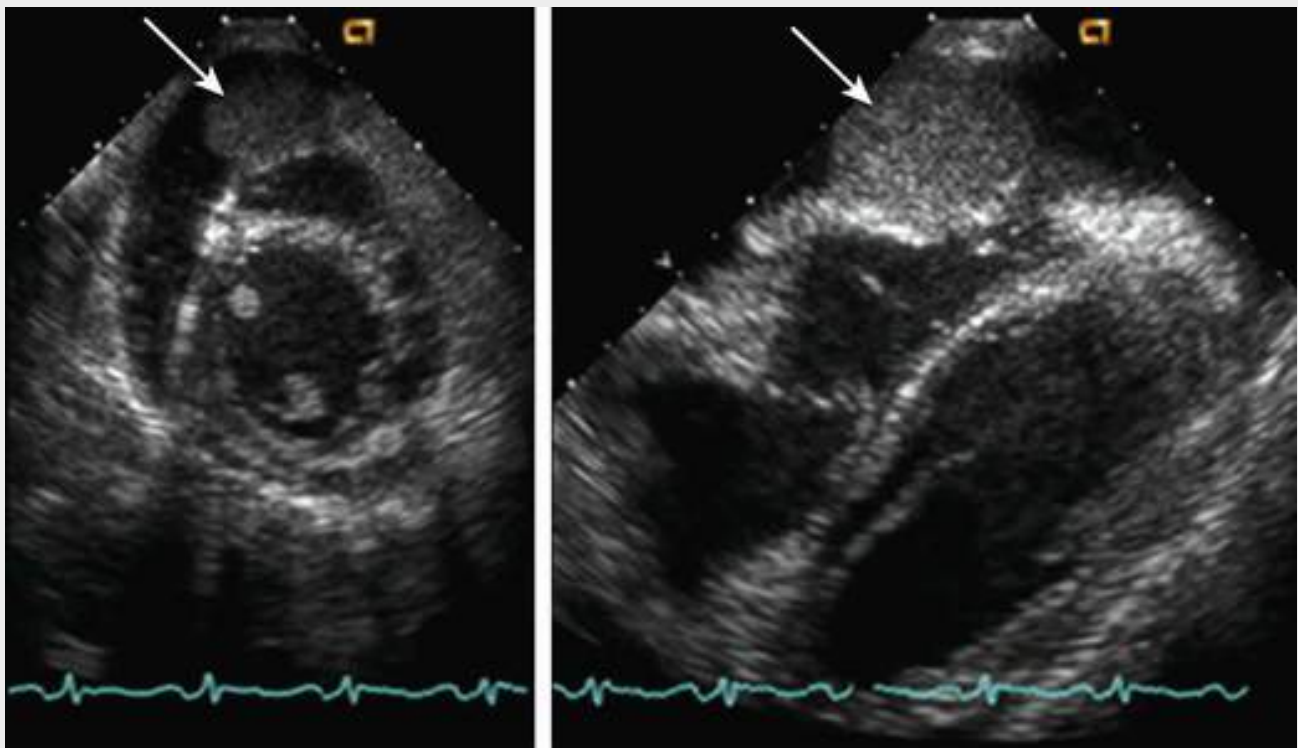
Subcostal echocardiograms showing a tumor metastasis (arrows) within the pericardial space and invading the right ventricular myocardium. The tumor is surrounded by pericardial effusion.
